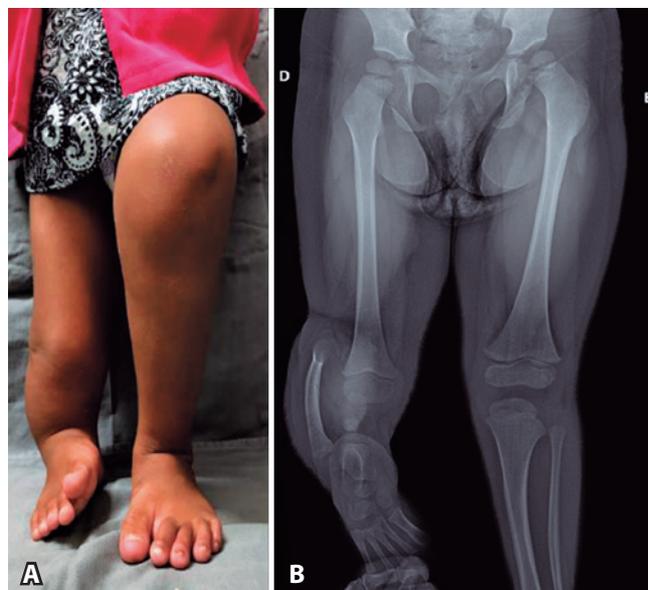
A) Preoperative clinical condition; B) Lower limb X-ray. Source: Authors' personal archive.
